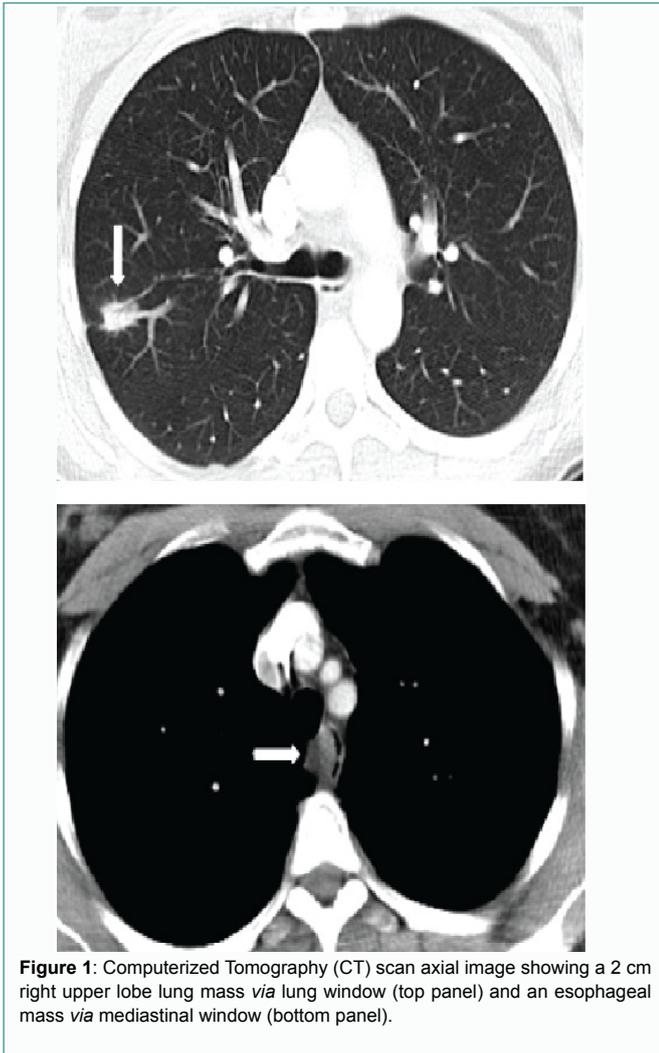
Computerized Tomography (CT) scan axial image showing a 2 cm right upper lobe lung mass via lung window (top panel) and an esophageal mass via mediastinal window (bottom panel).
